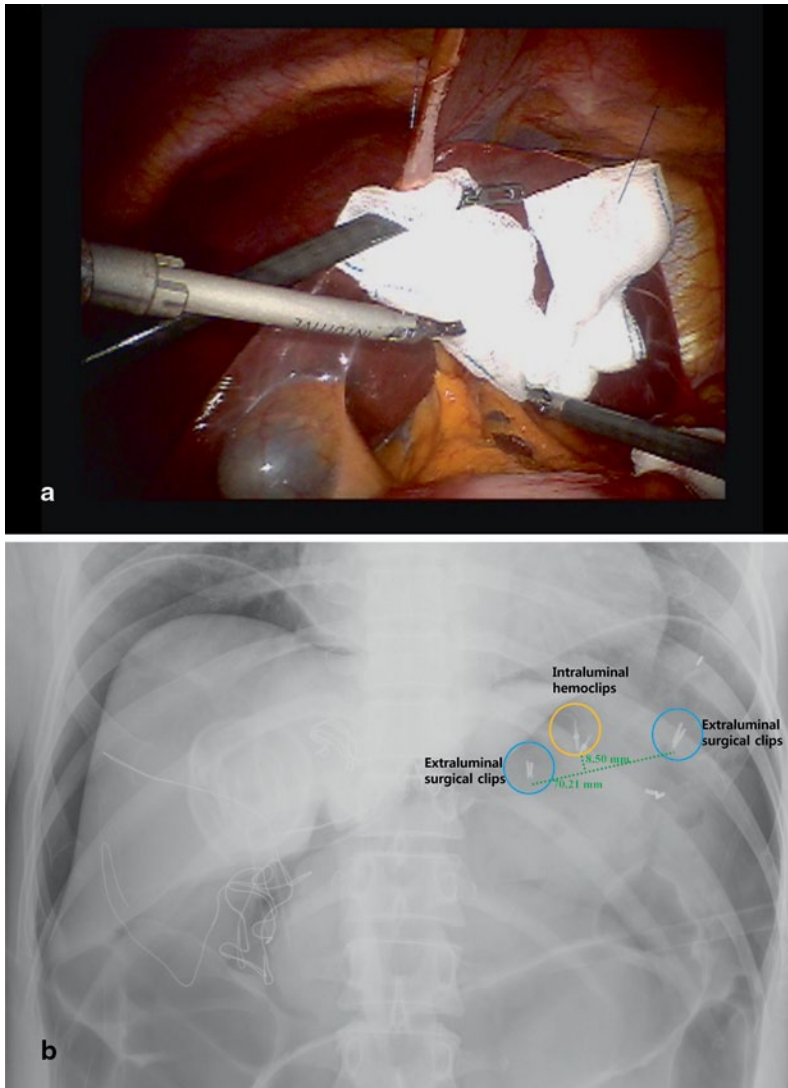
a Liver retraction with a suture-gauze technique b Intraoperative X-ray for measuring the distance between surgical clips and intraluminal hemoclips. In this case, total gastrectomy was required
